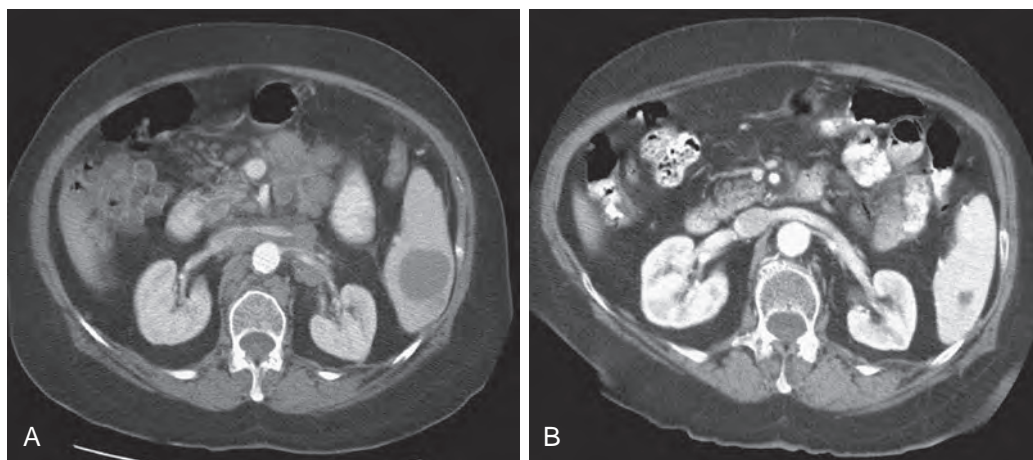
B-cell non-Hodgkin's lymphoma. A 74-year-old woman had a 2-month history of increasing general fatigue and low-grade fever. A. The enhanced CT scan during the portal venous phase shows an ill-defined, solitary, hypodense lesion in the inferior portion of the spleen. The spleen was moderately enlarged, and extensive para-aortic, paracaval, and abdominal lymphadenopathy is also visible. B. The enhanced CT scan of the upper abdomen 3 months after chemotherapy demonstrates marked improvement of the lymphadenopathy and decreased size of the splenic lesion.
